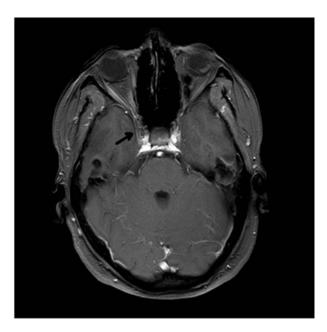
MRI examination 6 months after surgery. MRI revealed that the residual tumor had disappeared. MRI, magnetic resonance imaging.
